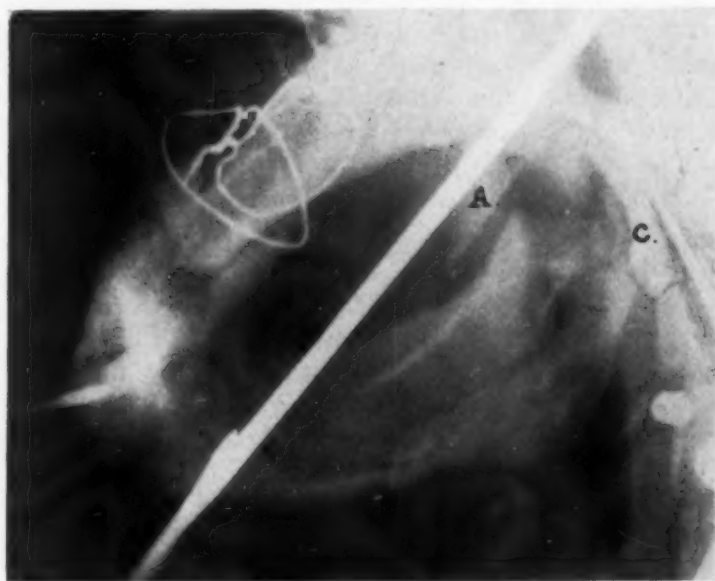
Postreduction x-ray shows subcondylar fracture, *C*, reduced, and fracture of coronoid process of ramus on left, *A*, unreduced.
